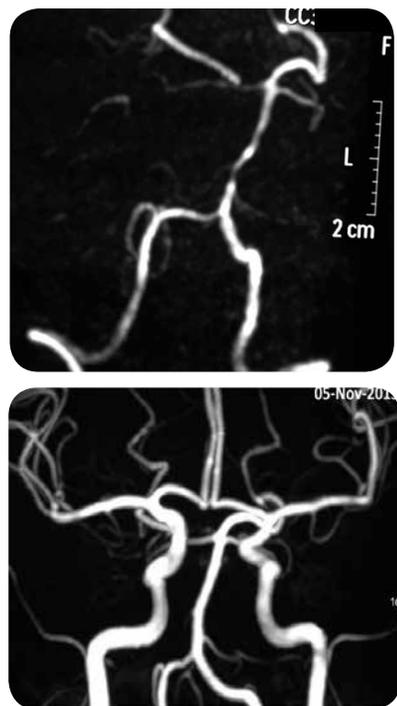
a) MRI: vasoconstriction of posterior circulation. b) Control MRI at 14 weeks: reversibility of initial angiographic abnormalities is observed.
